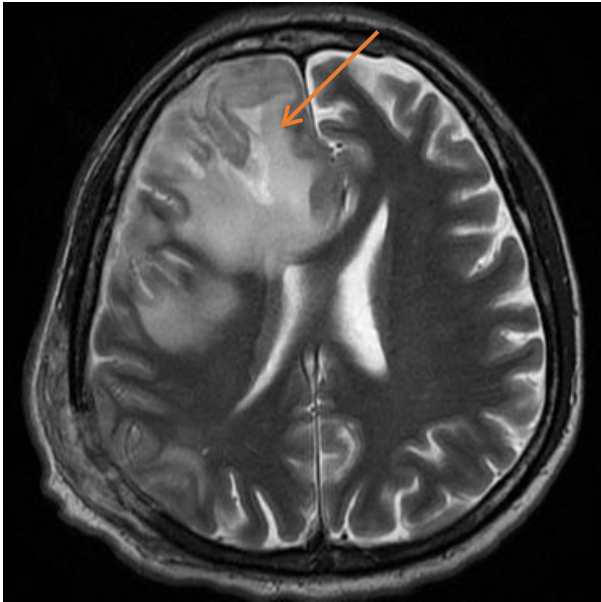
MRI Axial T2. Encapsulated right frontal abscess (red arrow) compressive on the frontal ventricular horns.
